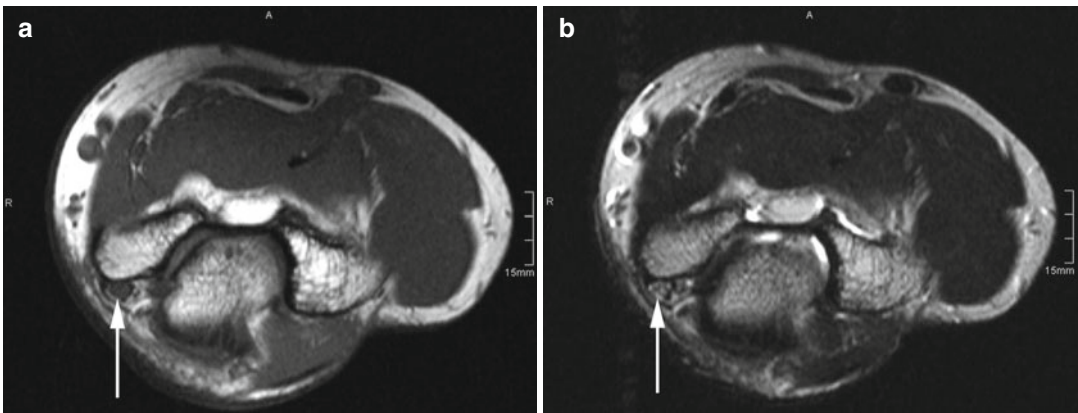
(a) Axial T1-weighted image of the elbow at the level of the humeral condyle. The *arrow* indicates an enlarged ulnar nerve surrounded by perineural fat and abutting the bone. (b) Axial T2-weighted image demonstrating edematous changes within the swollen nerve (*arrow*). (c) Axial reconstructions of a 3D T2*-weighted sequence (DESS 3D) with selective water
